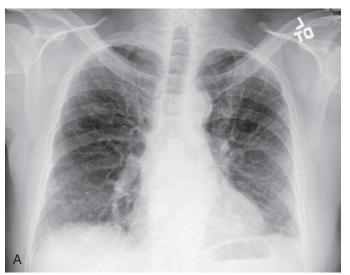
(A) Posteroanterior chest x-ray showing the characteristic features of idiopathic pulmonary fibrosis, a common interstitial lung disease. Notice the bilateral lower zone reticulonodular infiltrates and the loss of lung volume in the lower lobes. (B) Chest computed tomography image shows the peripheral nature of the fibrosis.
